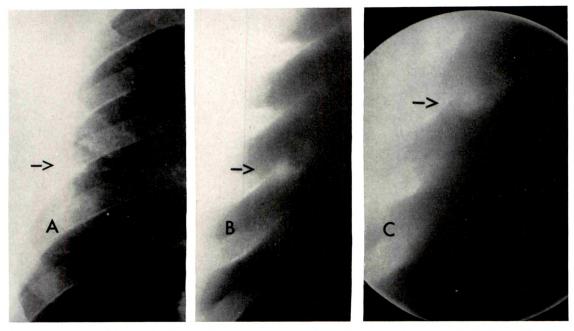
Case IV. A small peripheral density is seen on the plain roentgenogram (A), confirmed but not identified on the conventional linear laminagram (B) and clearly identified as a calcified granuloma on the polydirectional laminagram (C).
